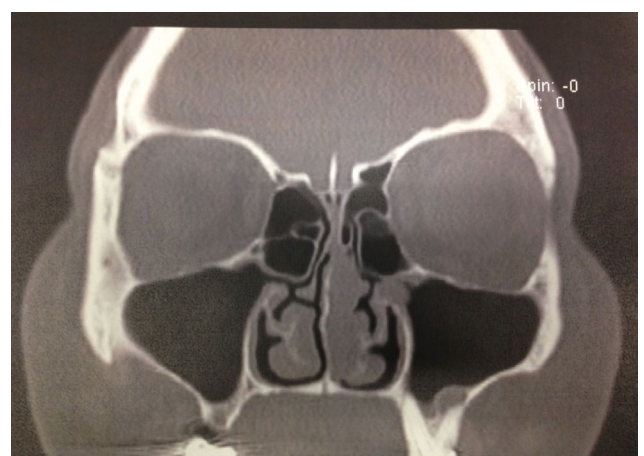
Coronal CT image demonstrating a polypoid soft tissue mass which seems to arise from medial wall of the left nasal cavity and partially obstructing the superior and mid nasal cavity.
